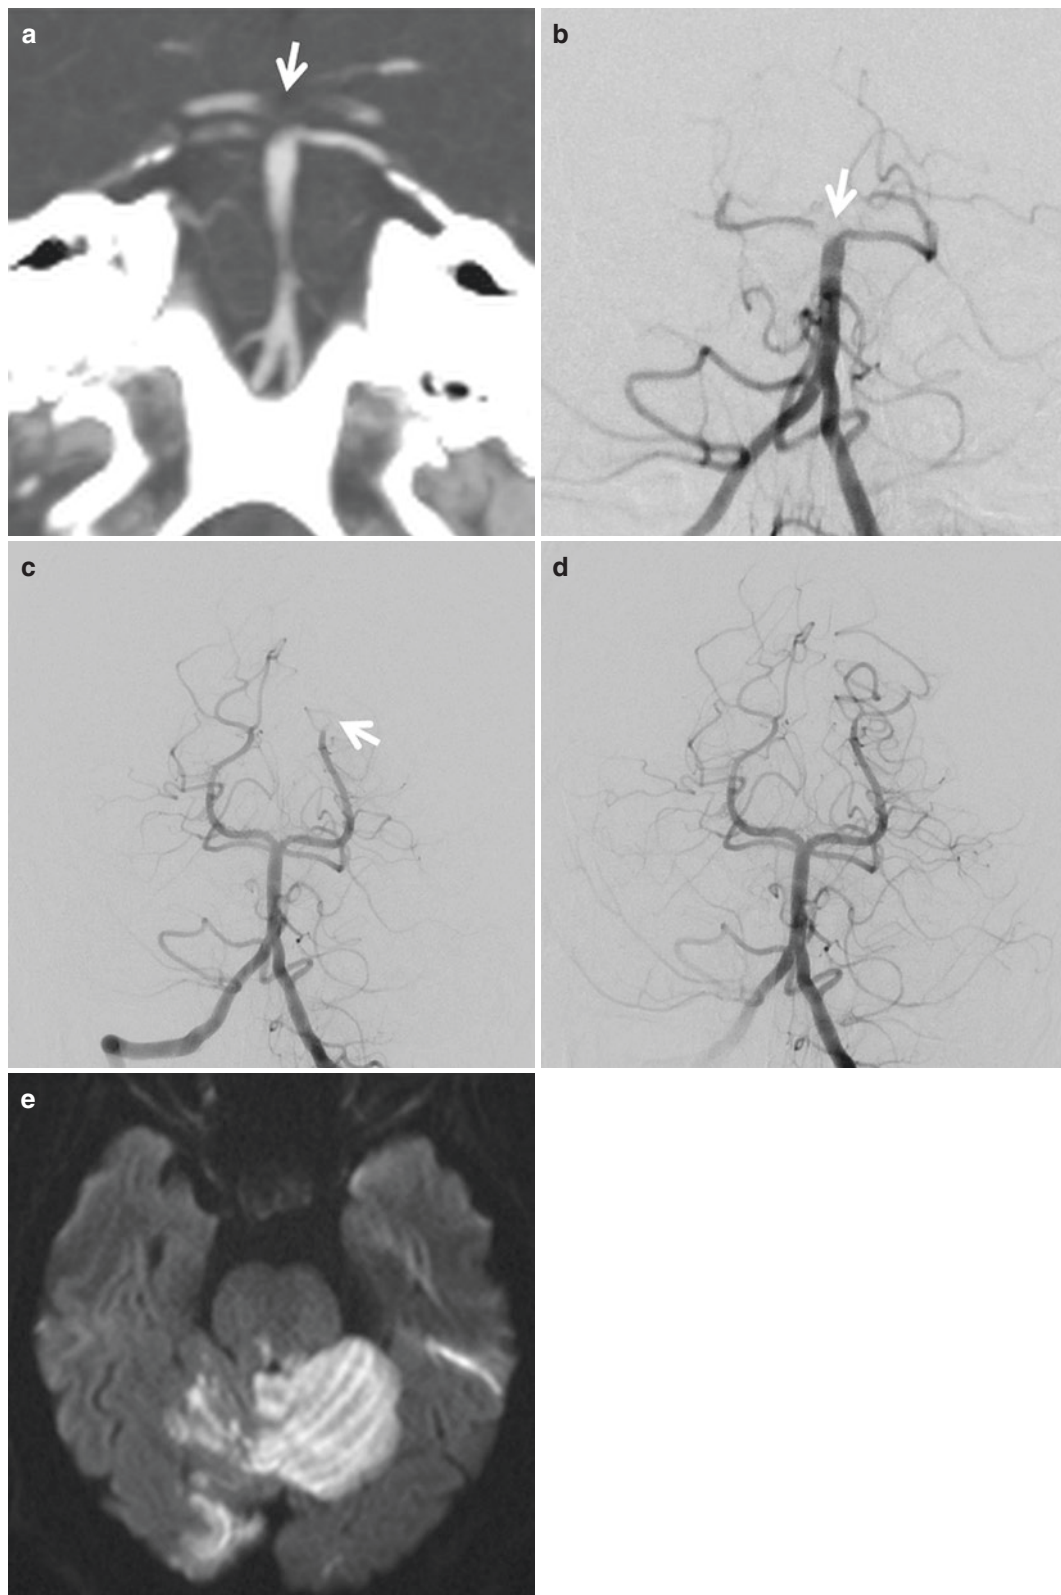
Basilar tip thrombosis. (a), Coronal CTA MIP demonstrates a thrombus at the tip of basilar artery extending to the origins of bilateral PCAs and right SCA (*arrow*). (b), Catheter angiography confirms the basilar tip thrombosis (*arrow*) involving bilateral PCA origins and occlusion of the bilateral SCAs. (c), Mechanical thrombectomy is performed, and post-thrombectomy angiogram demonstrates resolution of basilar thrombosis
